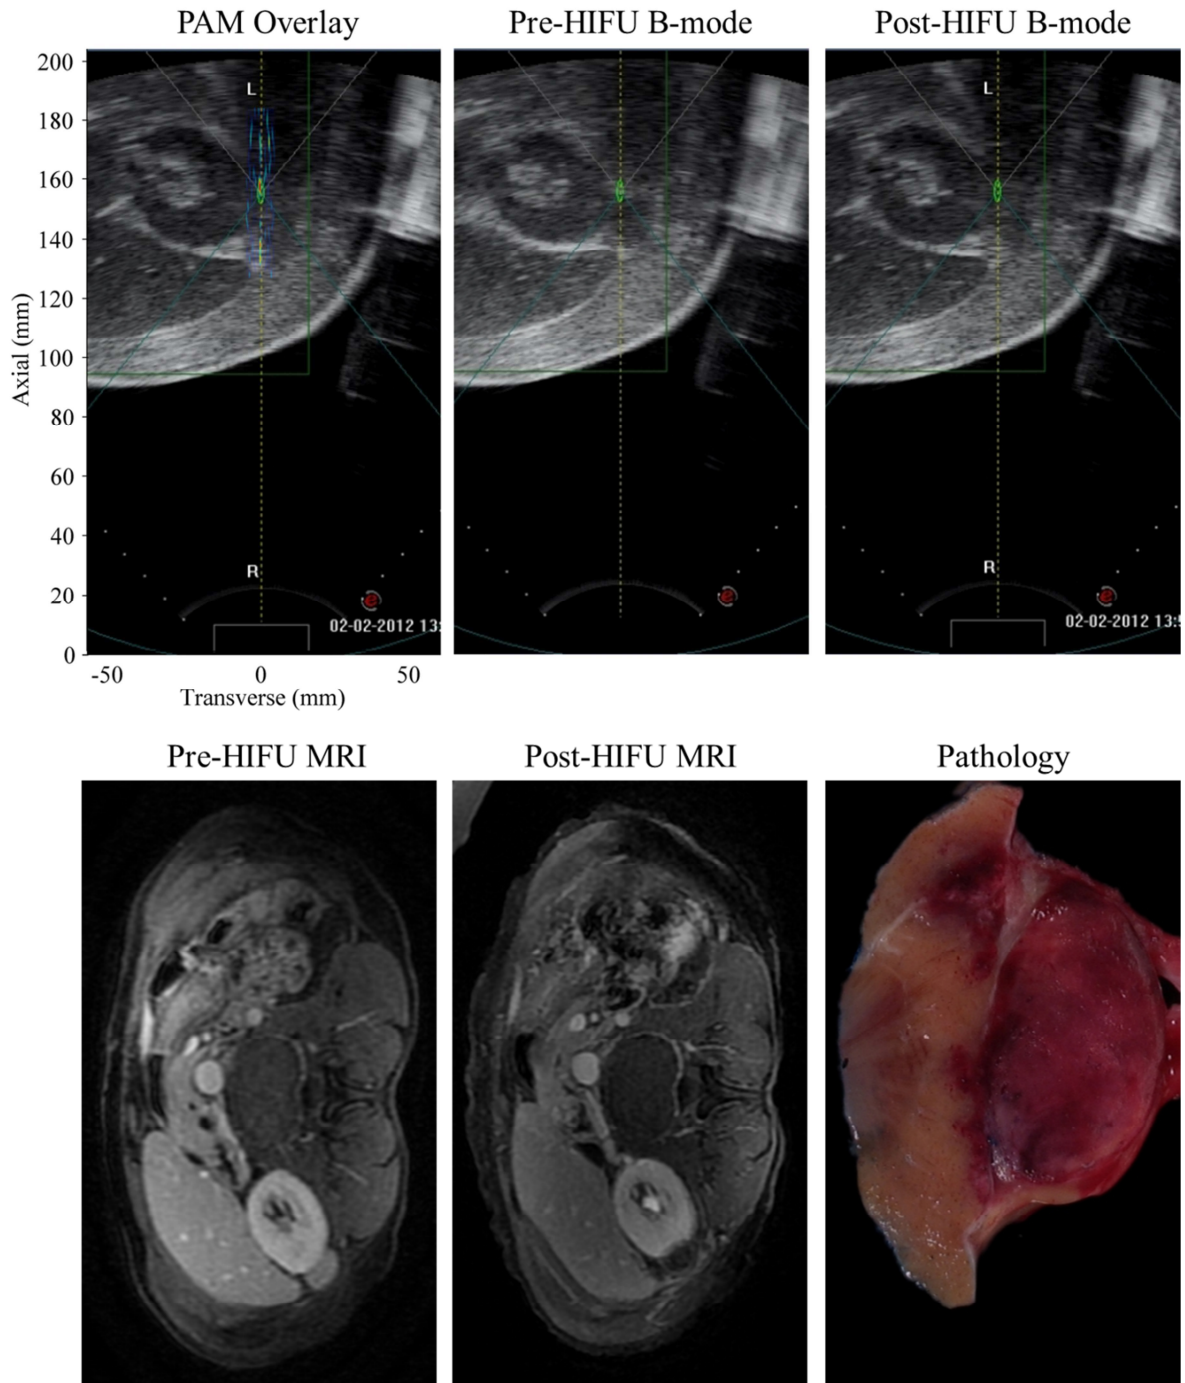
Diagnostic imaging and pathology of HIFU-treated renal tumour from Patient 5.39. Top row: B-mode image of 70W 2 second HIFU exposure showing overlaid harmonic map (left), pre-treatment image (middle) and post-treatment (right). Bottom row: LAVA MRI showing pre-HIFU (left) and post-HIFU (right) images with photograph of surgical resection pathology (right).
